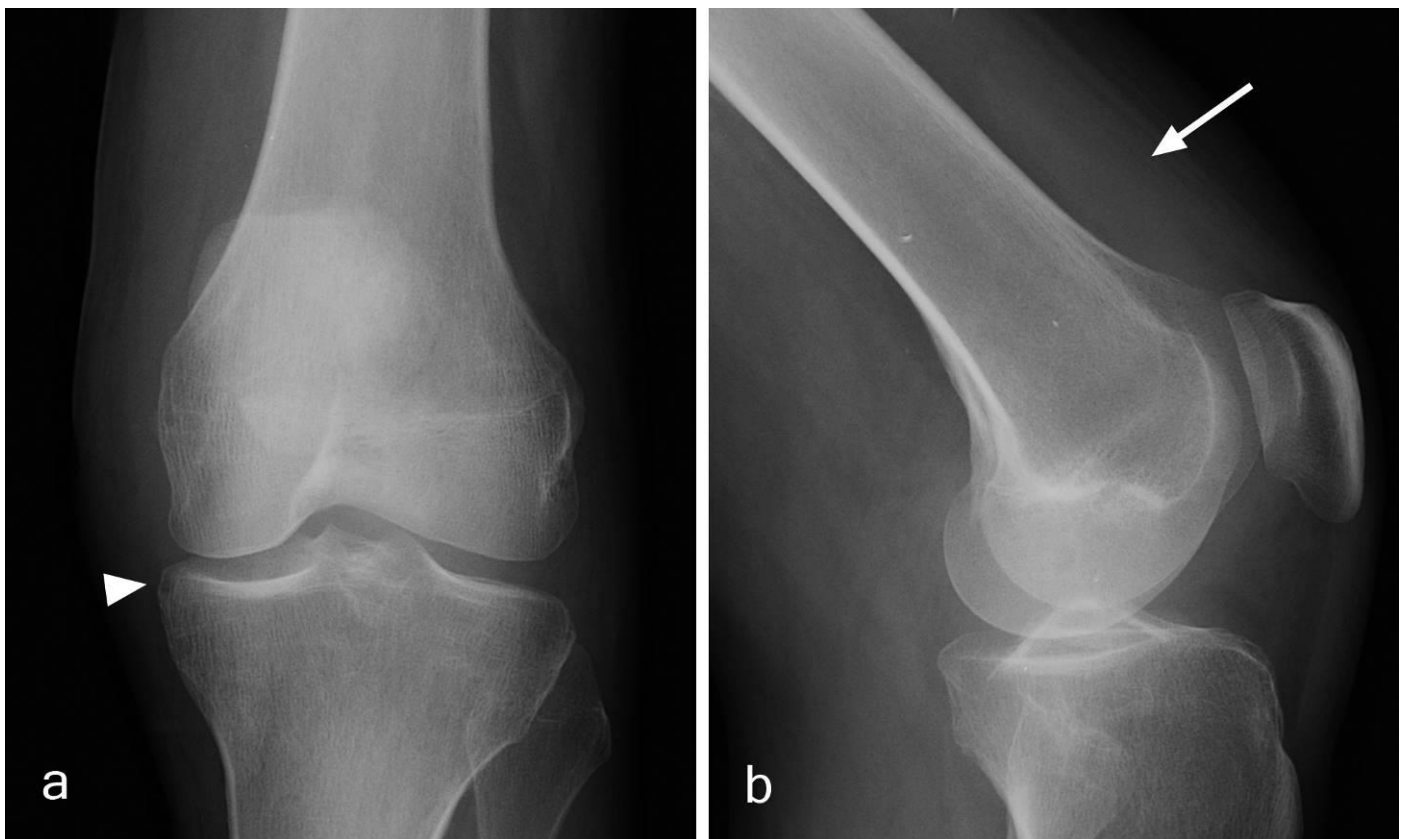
41-year-old woman with *Mycobacterium kansasii* synovitis and osteomyelitis of the knee. Findings: Anterior-posterior (a) and lateral (b) radiographs of the left knee performed on the patient's initial visit to the emergency department demonstrate a tiny medial marginal tibial erosion (arrowhead), and synovial effusion (arrow). Technique: kVp and mAs were not recorded.
